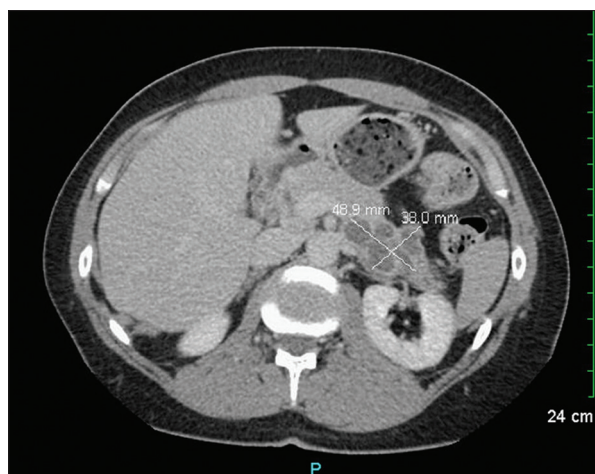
Computed tomography urogram. A complex lobulated cyst with septations or cystic mass of the posterior body of the pancreas of 4.9 cm × 3.8 cm × 2.6 cm diameter
